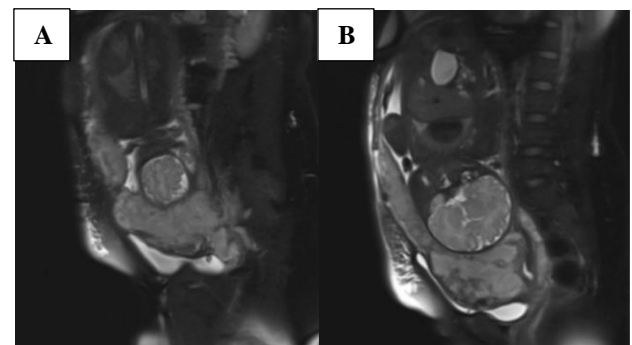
MR imaging findings. A) Abnormal bulging and bumpy contour of placenta; B) Numerous dark T2 intra placental bands.
